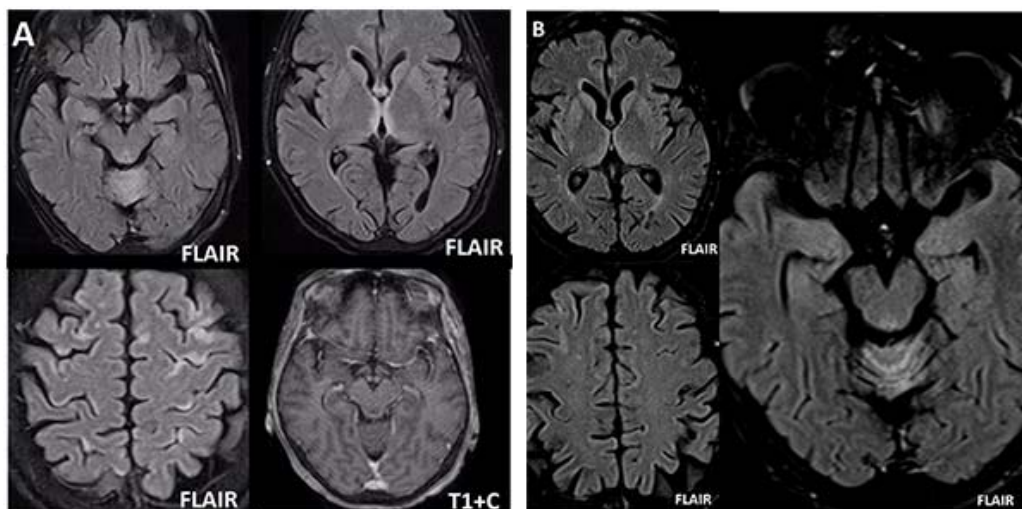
Symmetrical hyperintense signals on T2WI and FLAIR in the bilateral ventromedial thalamus, frontobasal region of third ventricle, midbrain, cerebellar vermis, bilateral cortical watershed zones. Figure 2B: Follow-up MRI showed mostly resolution of abnormal signals.
